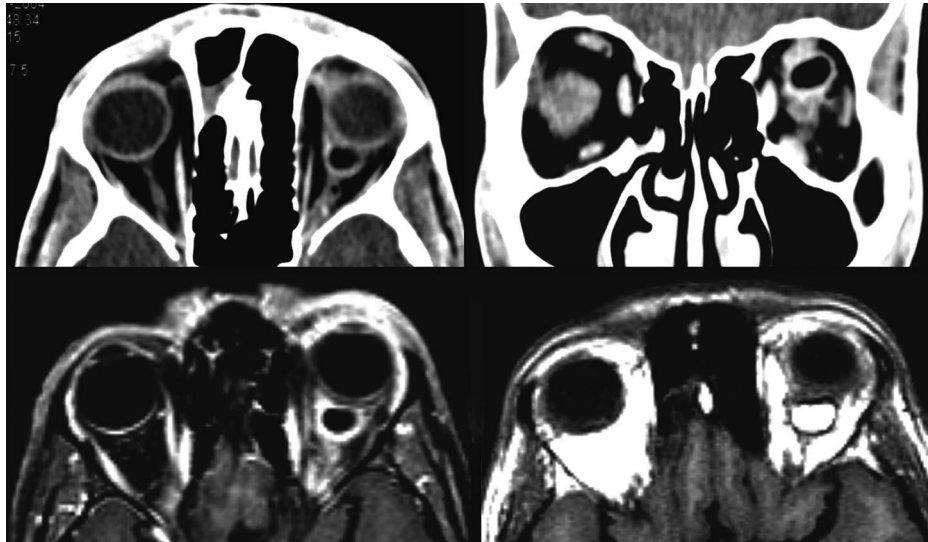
Top: Axial (left) and coronal (right) CT scans 8 months after the accident showing an intraconal cyst in the left orbit with a residual inflammatory response surrounding the cyst. Bottom: (left) T₁-weighted MRI without contrast: low saturation of the cyst's contents. With fat saturation and administration of gadolinium (right) the contents of the cyst show high saturation.
